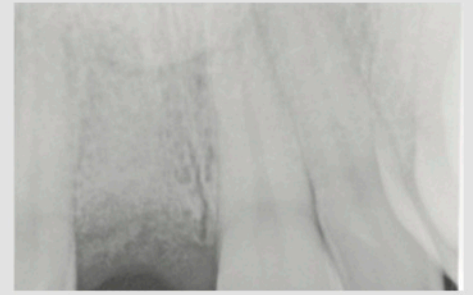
Three months after extraction and augmentation, the patient presented for implant placement. Hard tissue preservation was radiographically and clinically confirmed.
